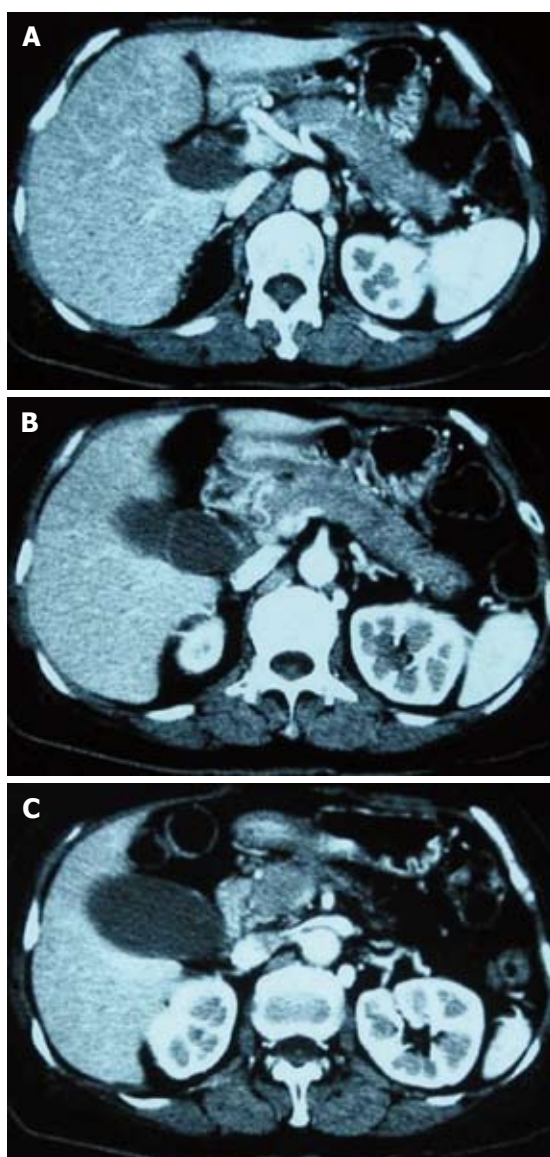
Abdominal CT before surgery. A low density area was observed throughout the entire pancreas, the common bile duct and main pancreatic duct were dilated, the intra-hepatic biliary duct was not dilated. CT: Computed tomography.
